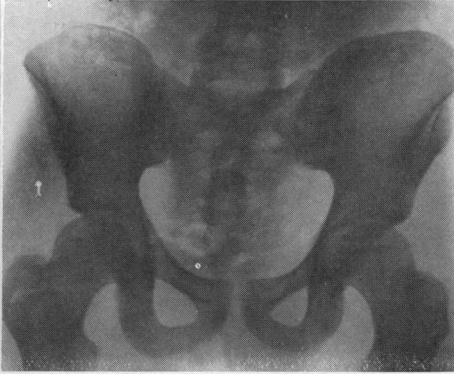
Roentgenogram taken of Case II directly after his injury.
